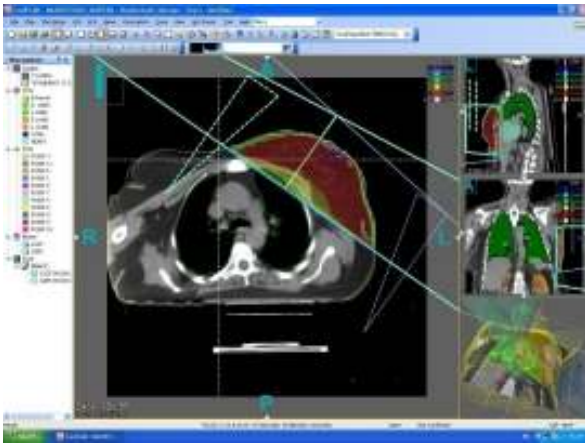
Patient with large, pendulous breast in lateral decubitus treatment position. Lateral decubitus isodose distribution with 15-degree wedge. Isodose curves for 6 and 15 MV x-rays (source-axis distance, 100 cm) using tangential breast portals without compensators. The lack of a separate IM field can result in irradiation of an excessive volume of lung, particularly in large-chested patients.
